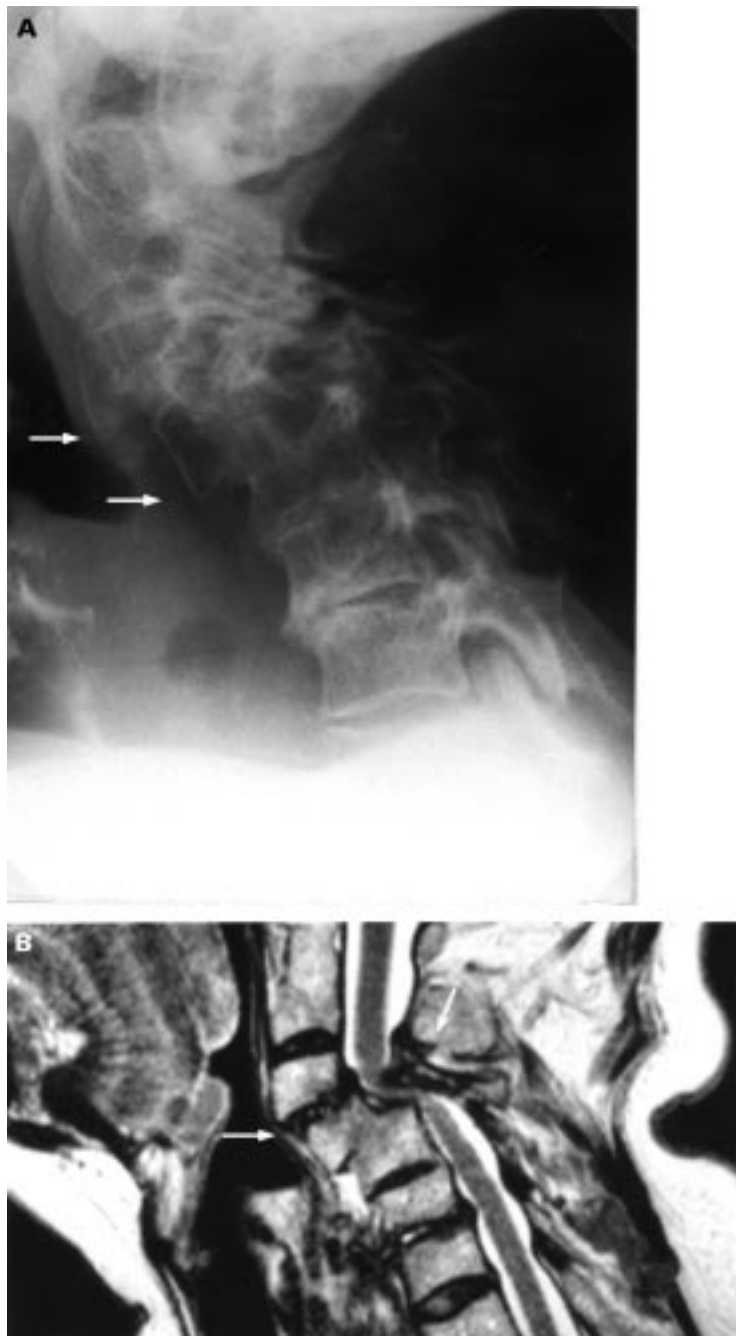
Lateral plain radiography in flexion (A) and T2 weighted sagittal MR image (B) of the cervical spine showing C3–C4 subluxation of 9 mm, stable C4–C5 subluxation of 8 mm with fusion of the vertebral bodies of C4 and C5, narrowing of the spinal subarachnoid space, and compression of the spinal cord.
